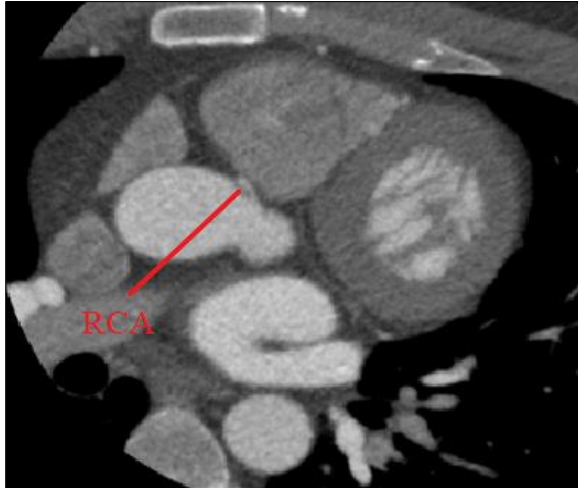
(a) CT axial plane showing the origin of the right coronary artery (RCA) from the left cusp.
